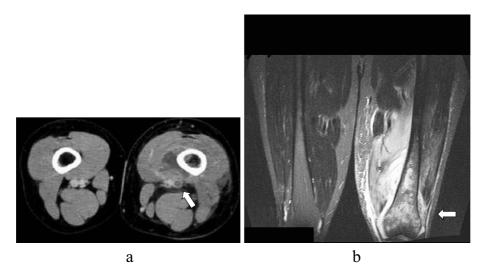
Contrast-enhanced computed tomography (a) and magnetic resonance (b) imaging of the lower extremities. Inflammation had spread around the left femoral bone, and thrombosis was evident in the left femoral vein (arrow, a). Magnetic resonance image showing osteomyelitis of the left thigh and spreading inflammation (arrow, b).
